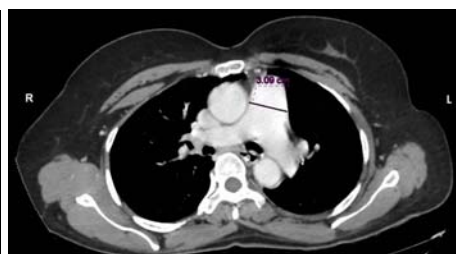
CT Thorax Showing Pulmonary Artery Dilatation
